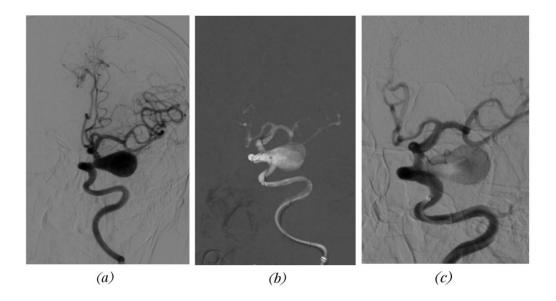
A 61-year-old woman was admitted to the National Brain Center Hospital with a complaint of headache that had been present for the past 10 years. After a Digital Subtraction Angiography (DSA) of the brain, a giant saccular aneurysm in the cavernous was found, with a size of 24.25mm (24.25/width x 16.76/height x 10.9/length mm, neck 6.41mm). (a) DSA images obtained before FD placement (b) CTA images obtained during FD placement (c) DSA images obtained after FD placement.
